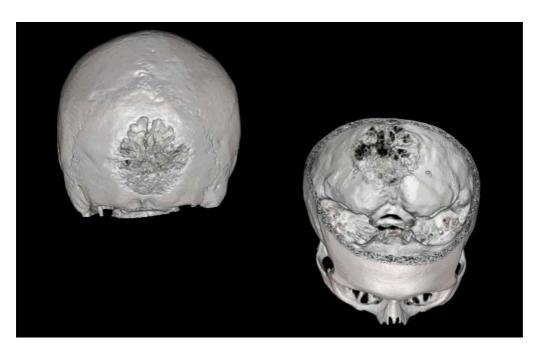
CT scan of a neoplastic lesion, with external (left) and 'cut-away' view (right).
